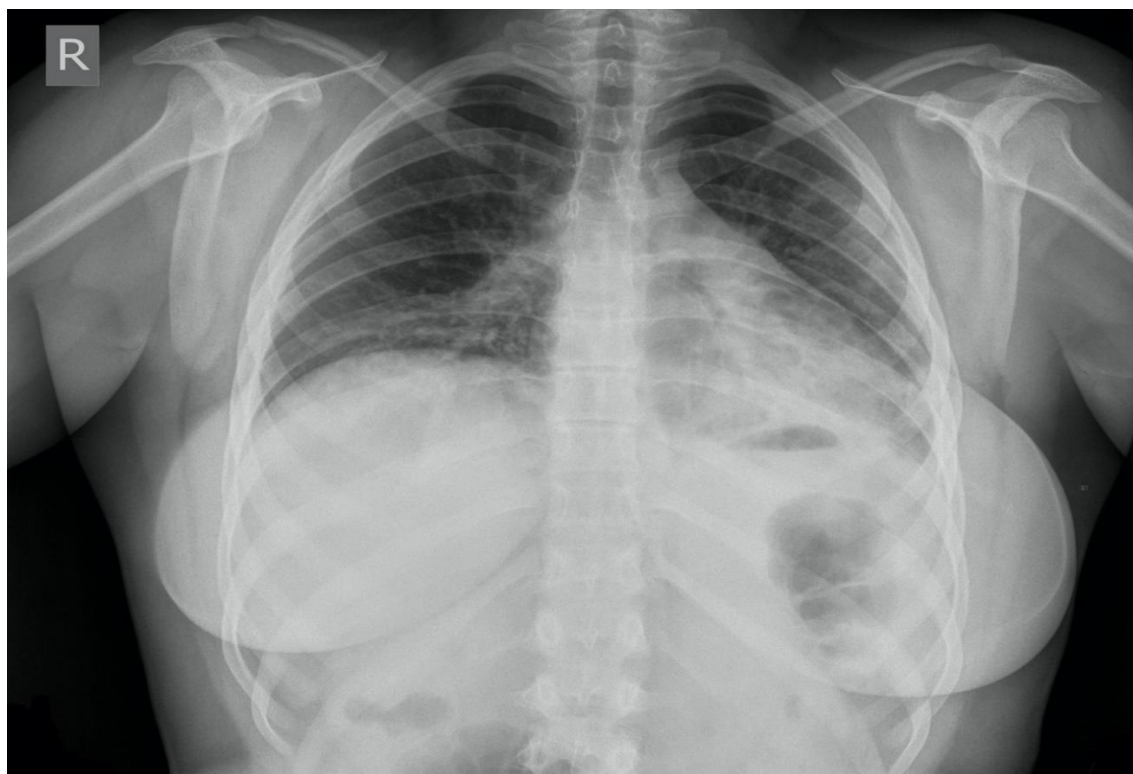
Chest X ray (CXR) on the day of admission in general hospital showed bilaterally pulmonary infiltration more to the left and basally. CT scan of the same patient is shown as well (Figure 2). Chest CT image after admission showed multiple patchy consolidations bilaterally, more to the left, bilaterally more to the posterior section, and basally, per type ground glass opacification.
